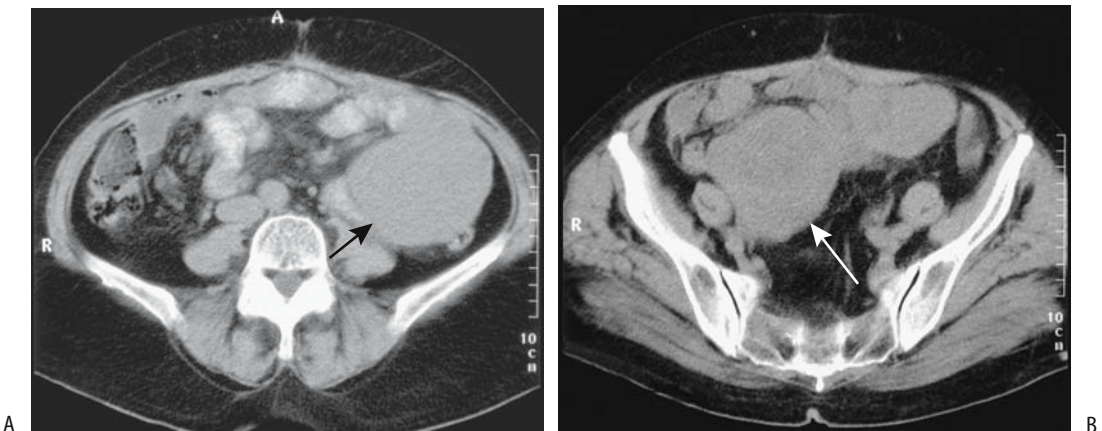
Mesenteric leiomyoblastoma. A,B: Noncontrast CT shows this soft tissue tumor extending from the left abdomen into the right lower quadrant (arrows). (Courtesy of Algidas Basevicius, M.D., Kaunas Medical University, Kaunas, Lithuania.)
